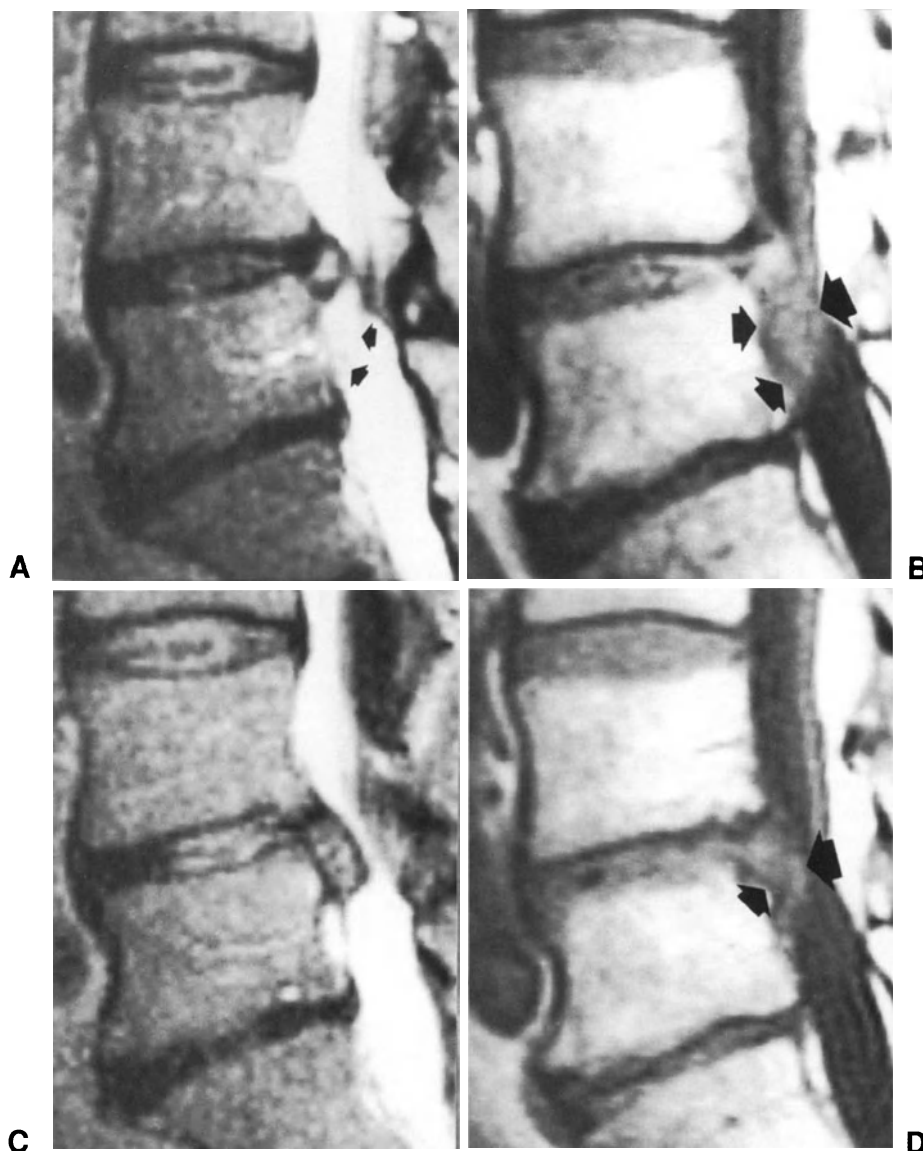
MRI scans of patients with large recurrent herniation at L4-L5 level. (A) and (B) Preoperative turbo spin-echo T2-weighted and T1-weighted sagittal images, respectively, showing, caudally to the L4-L5 level, a large disc fragment (arrows) with an increased signal intensity in the T2 sequence. (C) and (D) Turbo spin-echo T2-weighted and T1-weighted sagittal images, respectively, carried out 11 months after surgery, showing, at L4-L5 level, a large recurrent herniation which is almost completely extruded into the spinal canal (arrows).
